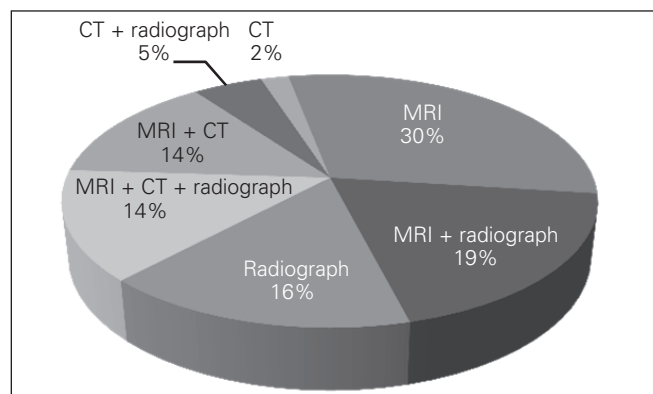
Combinations of imaging required for accepting a spine-related referral among respondents who indicated that they require imaging to accompany a new referral, $n = 43$. CT = computed tomography; MRI = magnetic resonance imaging.
